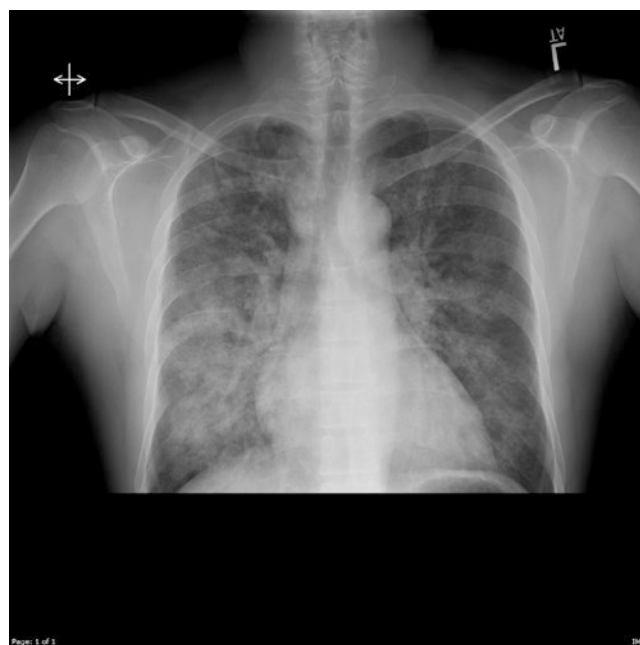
Chest X-ray at initial presentation showing multifocal bilateral alveolar opacities
